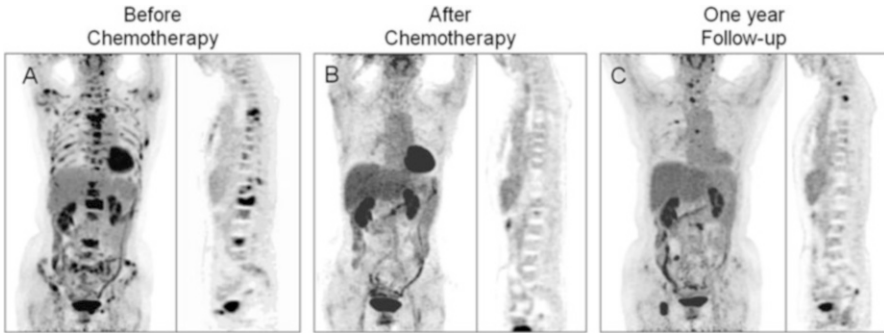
(a) PET/CT showed increased FDG uptake in multiple bones, including sternum, vertebrae, ribs, pelvis, etc. with maximum SUV of 6.65 in the left clavicle, 11.70 in the L1 vertebra, 5.18 in the ribs, and 5.40 in the right ilium. (b) PET/CT images showed normal FDG uptake in the whole body. (c) PET/CT images presented intensive FDG uptake in bowels with SUVmax of 5.69–10.22 in bones
